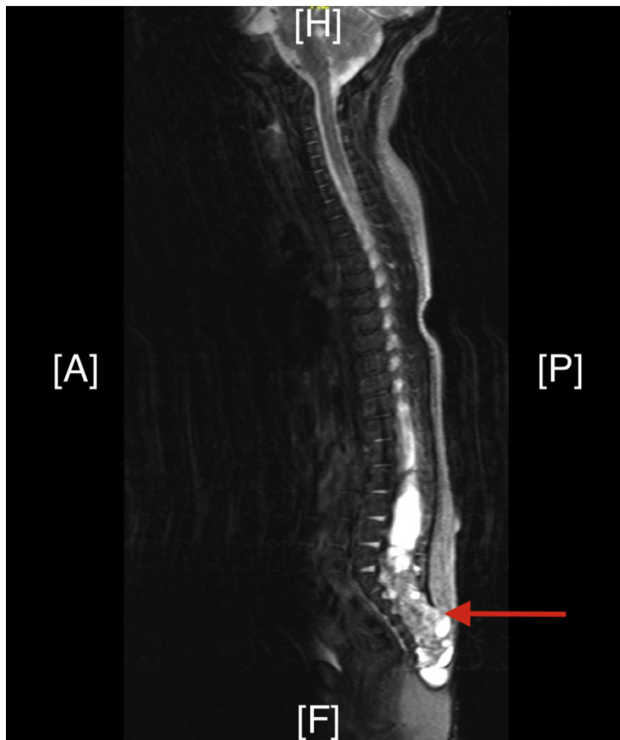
Sagittal T2-weighted preoperative MRI showing a heterogenous mass, causing compression of the sacral nerve roots (red arrow). A = anterior, P = posterior, H = head, F = foot.
